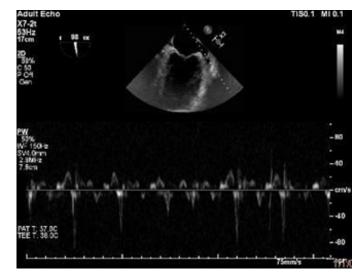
Transesophageal echocardiography. Midesophageal view at 98° with pulsed Doppler. The velocity inside the LAA is > 80cm/s.
